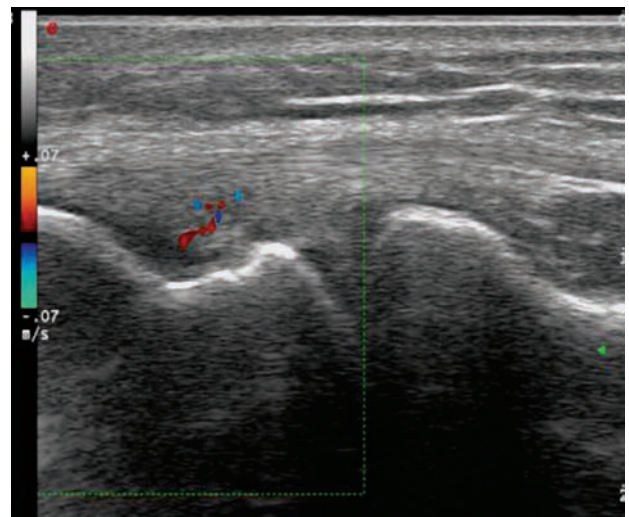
Ultrasound scan before  $O_2-O_3$  treatment.
